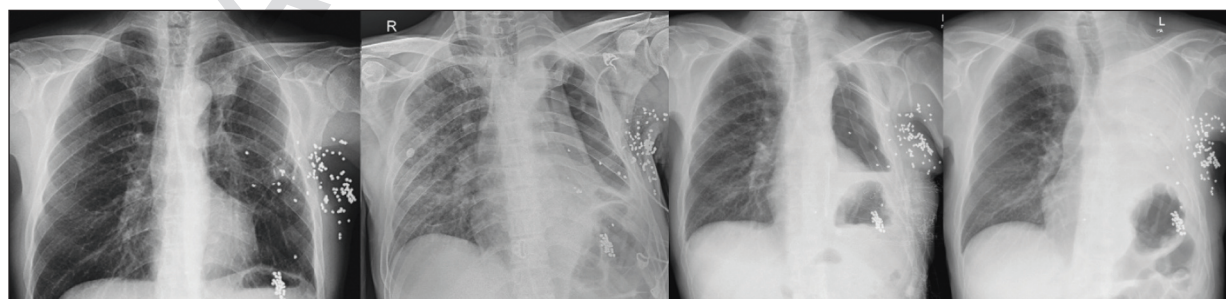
The patient's serial chest radiographs (from left to right) include: the preoperative radiograph before initial surgery; the image obtained before pneumonectomy demonstrating pneumonia in the right lung; the immediate postoperative image after pneumonectomy; and the radiograph taken at the 3-month follow-up visit
